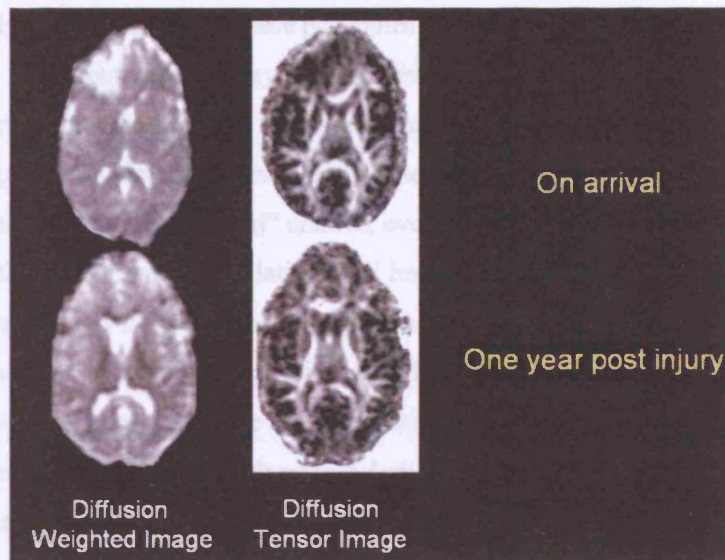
DTI images from one of our patients imaged acutely and at one year after head injury. Diffusion weighted images (left), and DTI, FA map (right), obtained within 24 hours of head injury demonstrate the value of DTI imaging in demonstrating axonal injury. The loss of white matter anisotropy in the right frontal region is evident on the FA map, and coincides with a hyperintense lesion on the DWI frame. Follow up DTI at one year (lower image pair) show that the white matter tracts have, in the main, survived intact.
